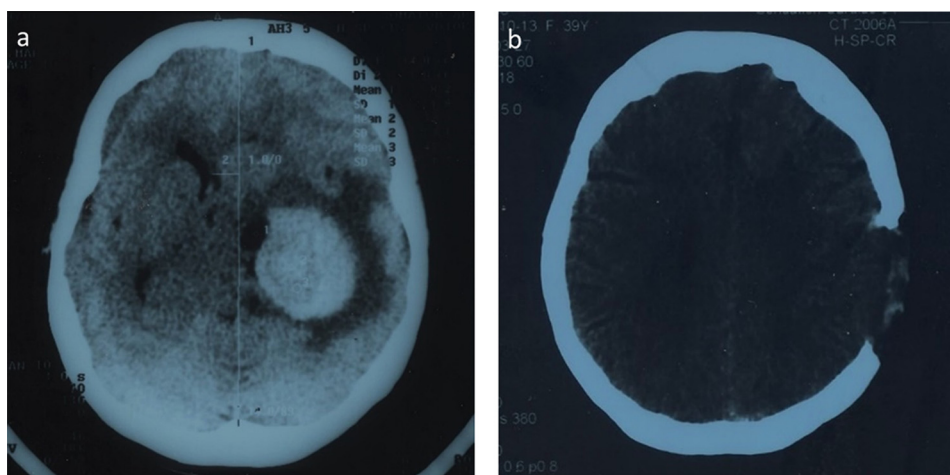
Brain imaging of the patient with melanoma metastasis: a. A computed tomography scan in 2006 revealed a solid tumour in the left hemisphere, b. The brain of the patient after the first resection.
